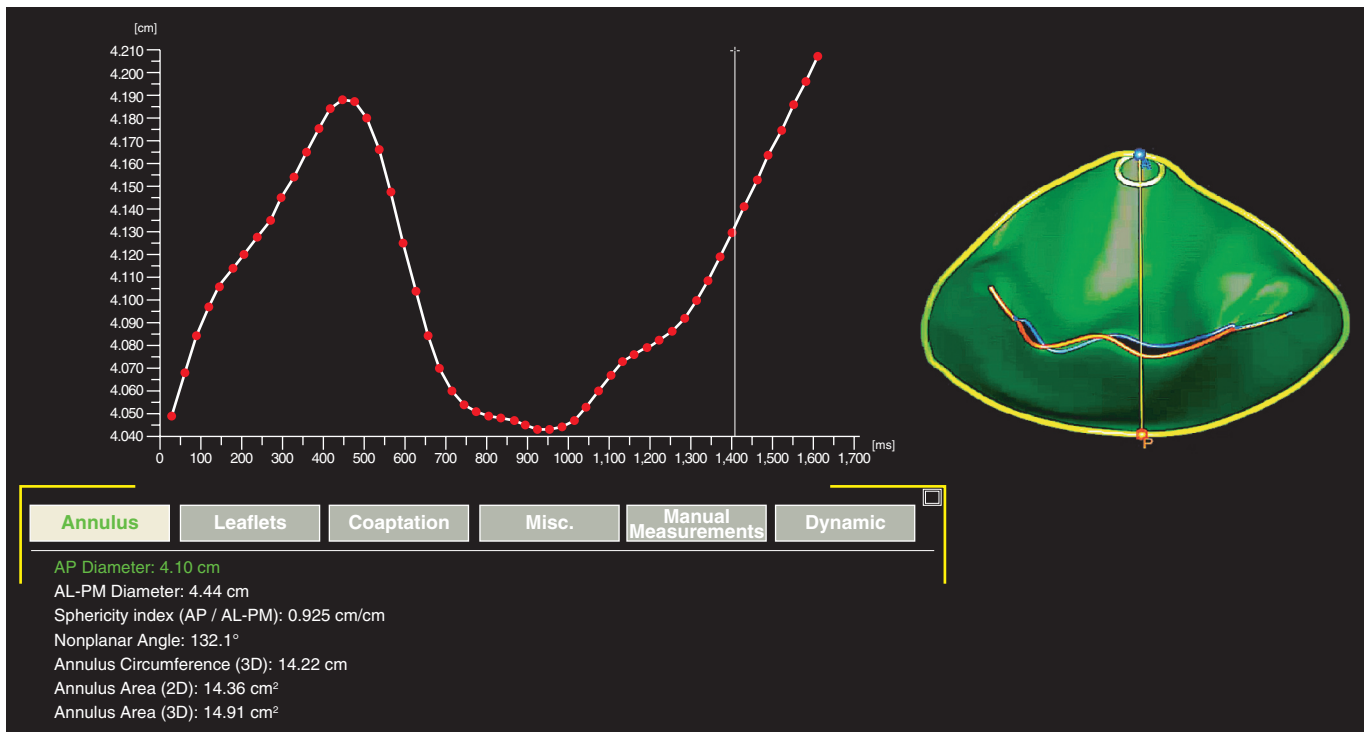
■ AP diameter. Three-dimensional echocardiographic imaging may allow for better visualization of heart anatomy and the changes it undergoes throughout the cardiac cycle. A three-dimensional reconstruction of the mitral valve and the changes it undergoes in its AP annular diameter is demonstrated here. AL, Anterolateral; AP, anteroposterior; PM, posteromedial.
